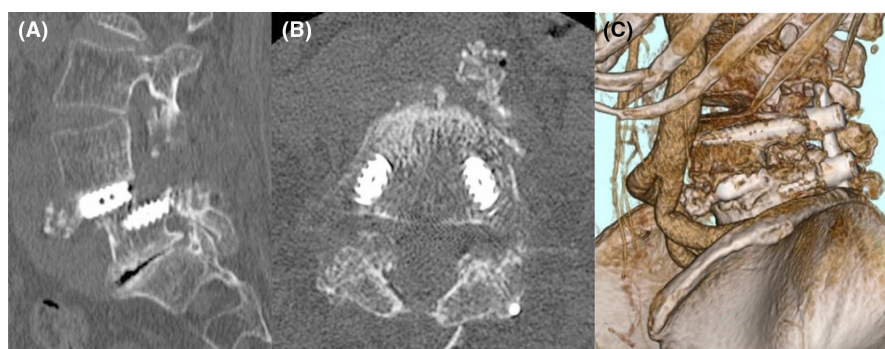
Postoperative plain CT (A: sagittal image, B: axial image) and 3D CT VRT (C) of case 2 showed anterior migration of the grafted bone, but there was no obvious compression of the vessels by the grafted bone (Figure 2): open arrow, graft bone.
